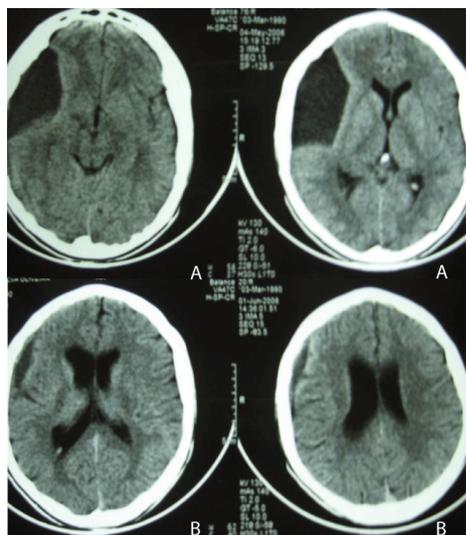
CT of brain with contrast (axial cuts) showing the evolution of epidural abscess in the right temporal lobe: A) homogeneous epidural collection, not captante of contrast medium, measuring 6.24 x 3.48 cm; B) cortico-subcortical hypodensity with peripheral uptake of contrast medium, measuring 3.78 x 1.39 cm.
